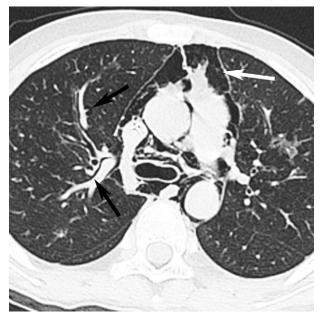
Complex ALS on CT in a 11-year-old male patient with acute lymphoblastic leukemia with a history of allo-HSCT, and with a conservative treatment duration of 33 days. PIE-linear air shadow around bronchial vascular bundles (black arrow), PM- gas in mediastinal (white arrow). With BOOP in both lungs. Allo-HSCT=allogenic hematopoietic stem cell transplantation, ALS=air leak syndrome, BOOP=bronchiolitis obliterans organizing pneumonia, CT=computed tomography, PIE=pulmonary interstitial emphysema, PM=pneumomediastinum.
